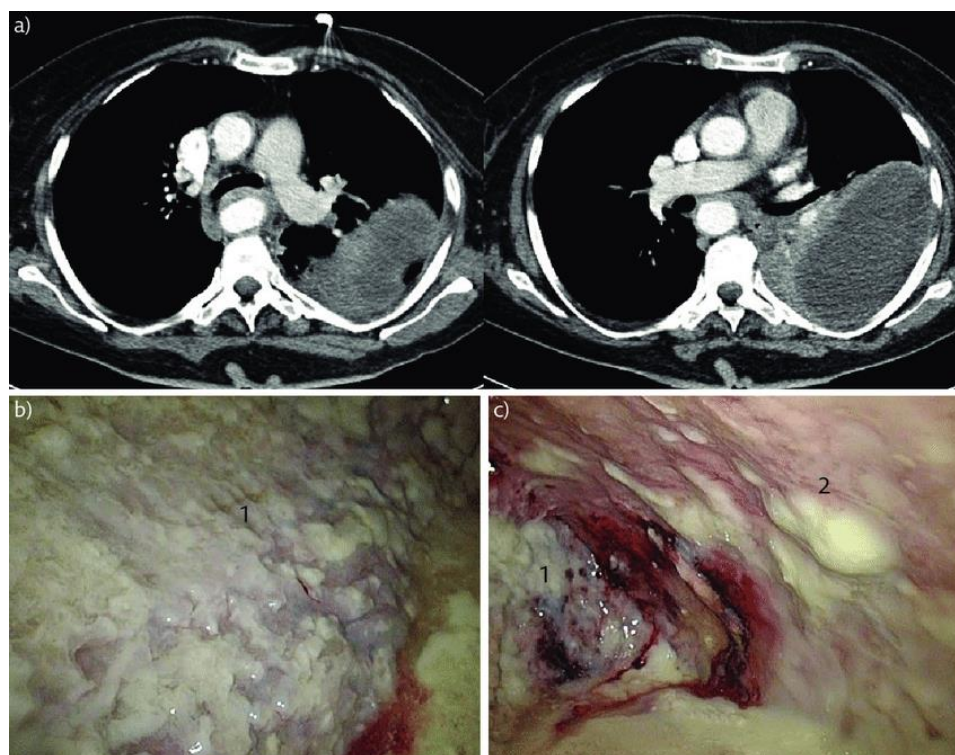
VATS decortication in pleural empyema stage III. a) Pre-operative CT of the thorax; b and c) operative views with thick fibrin layer over the parietal pleura and cortex overlying the lung. 1: lung; 2: chest wall. [29].
